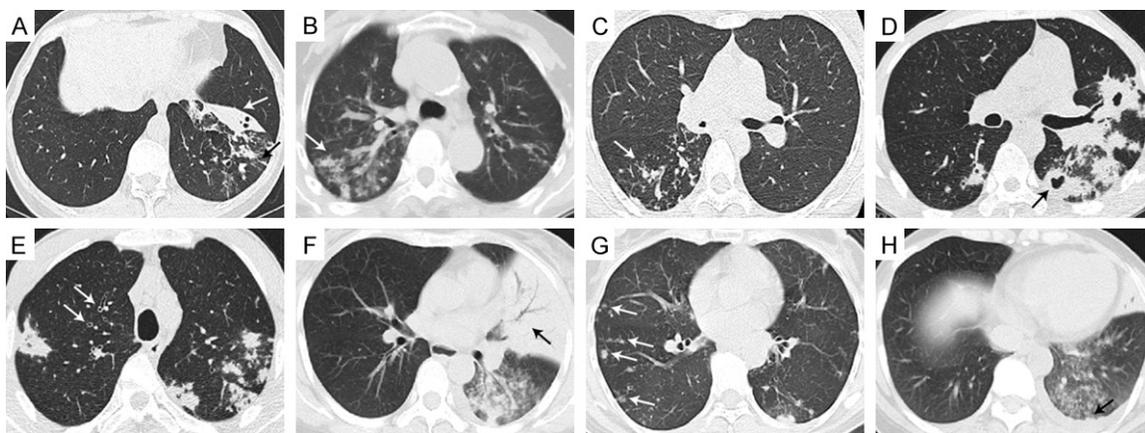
Typical CT findings for pulmonary tuberculosis. (A) Parenchymal linear (black arrow) and patchy (white arrow) consolidation. Tuberculosis infection (white arrows) in the apical and posterior segments of the right upper lobe (B), and the superior segments of the right lower lobe (C). (D) A cavitation in the left lung (black arrow), surrounded by irregular thick walls. (E) Bronchiectasis in the right lung (white arrows) on thin-section CT scan. (F) Obstructive atelectasis (black arrow) and pneumonia in the left lung. (G) Multiple nodules in the right lung (white arrows). (H) Tuberculosis infection in the left lung, accompanied with unilateral pleural fluid (black arrow).
